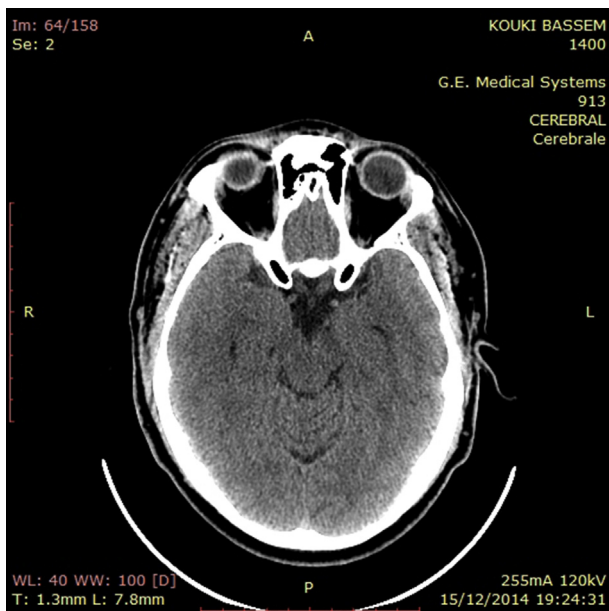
The absence of calcifications in the temporal lobes assessed by the CT scan of the brain.
